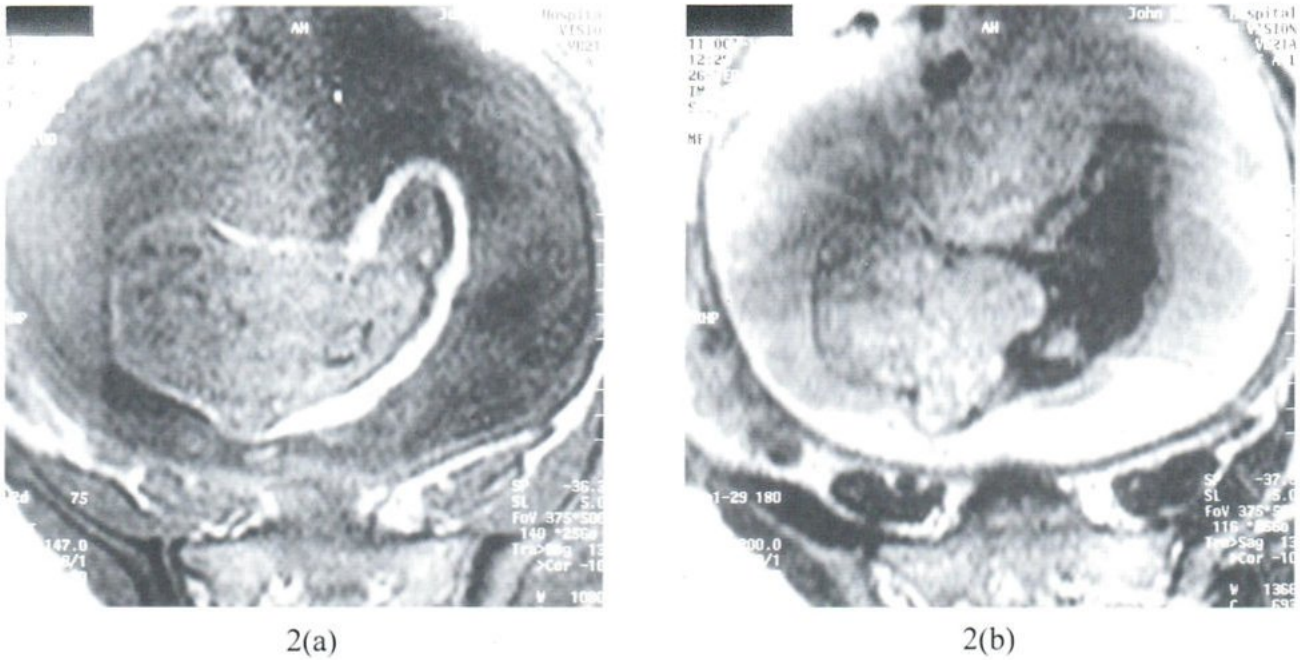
T1-weighted (a) and T2-weighted (b) axial images demonstrate a large lobulated mass arising from the left anterolateral aspect of the foetal neck. Curvilinear signal void represents calcification.
